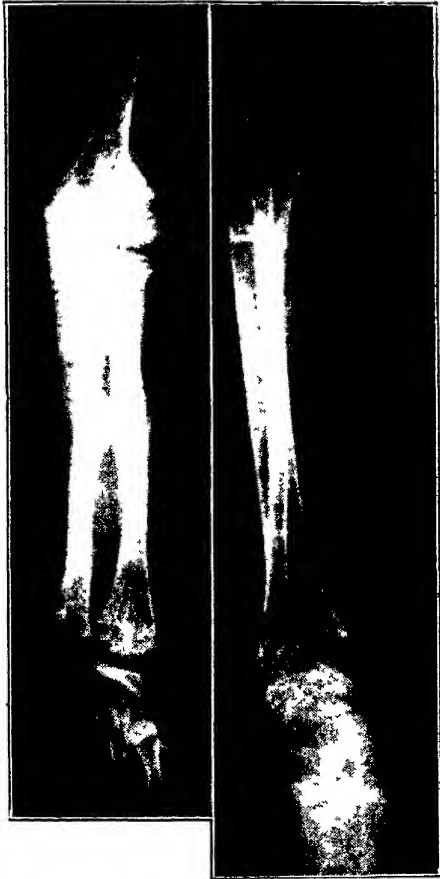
Roentgenograms of forearms, wrist and leg of W. D. made in December, 1937, 8 years after the onset of rickets. Epiphyses are irregular and show some deposition of calcium in rachitic zone. The bones, particularly of leg, show marked osteoporosis. (Bakwin, Bodansky and Schorr: *Am J. Dis. Child*)
